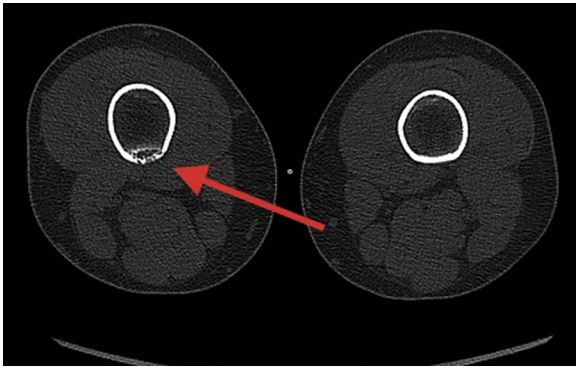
The axial CT view of the small areas of osteolysis along the rear edge of the intermediate and distal diaphyses of the right femur.
